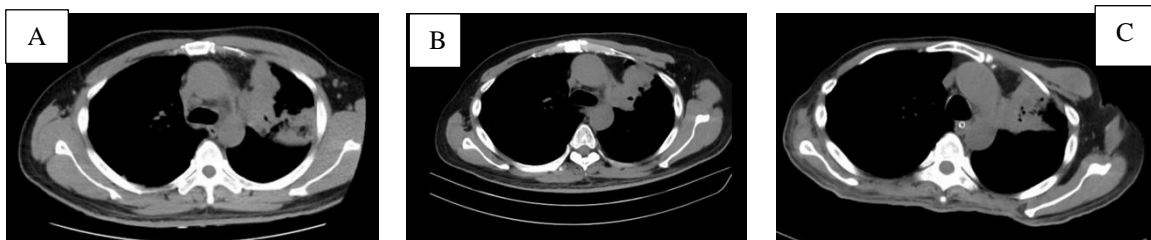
(A). Chest CT Scan prior to diagnostic bronchoscopy procedure, (B). Chest CT Scan after 4 cycles of chemotherapy – partial response, (C). Chest CT Scan after 6 cycles of chemotherapy – progressive disease.
